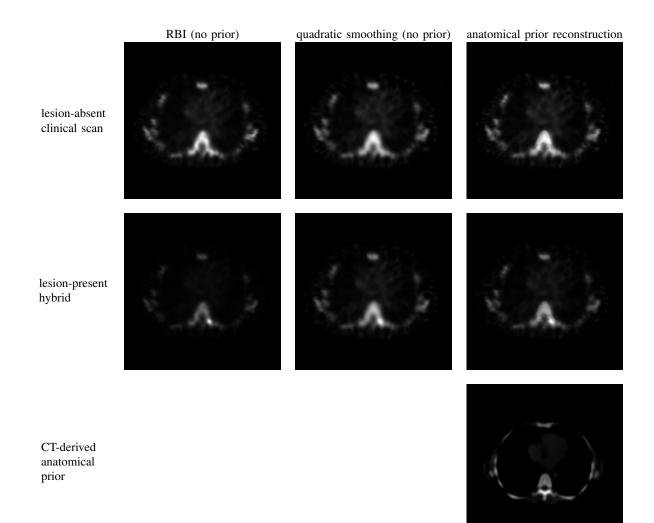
Reconstructed transaxial slice through the center of a lesion, together with the CT-derived map used as an anatomical prior. This is the same clinical background and hybrid shown in figure 2.
